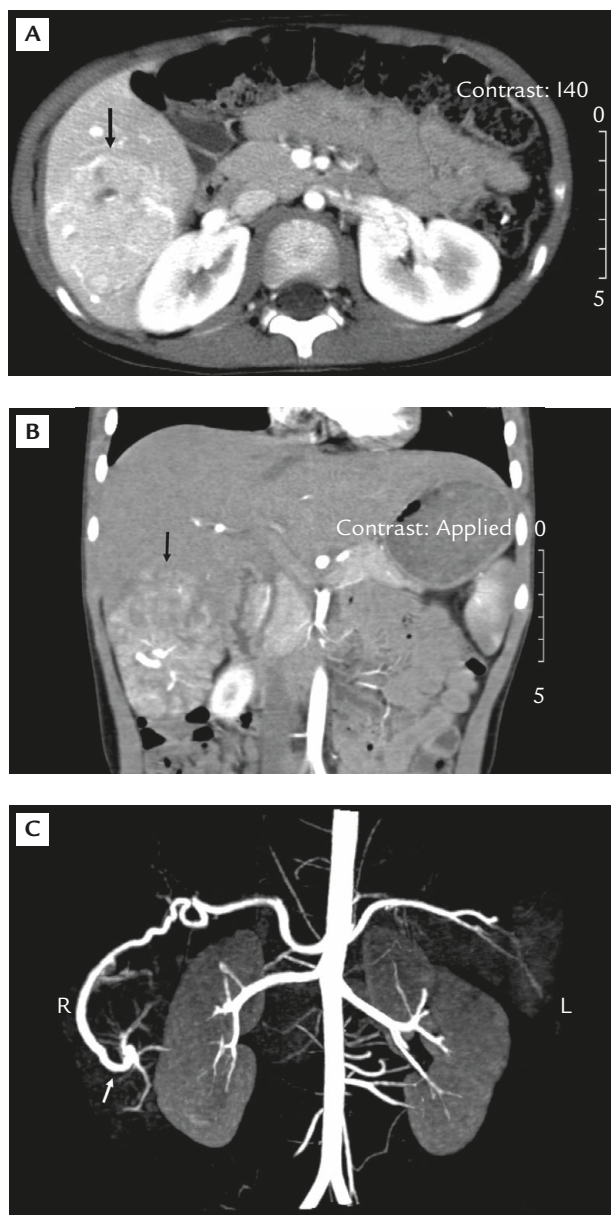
(A and B) Dynamic computed tomography of the liver shows a lobulated right hepatic tumor (arrow) with a dilated feeding vessel from the right hepatic artery during the arterial phase. (C) Computed tomographic angiography demonstrates a spoke-wheel pattern (arrow) that corresponded to radiated arteries.
